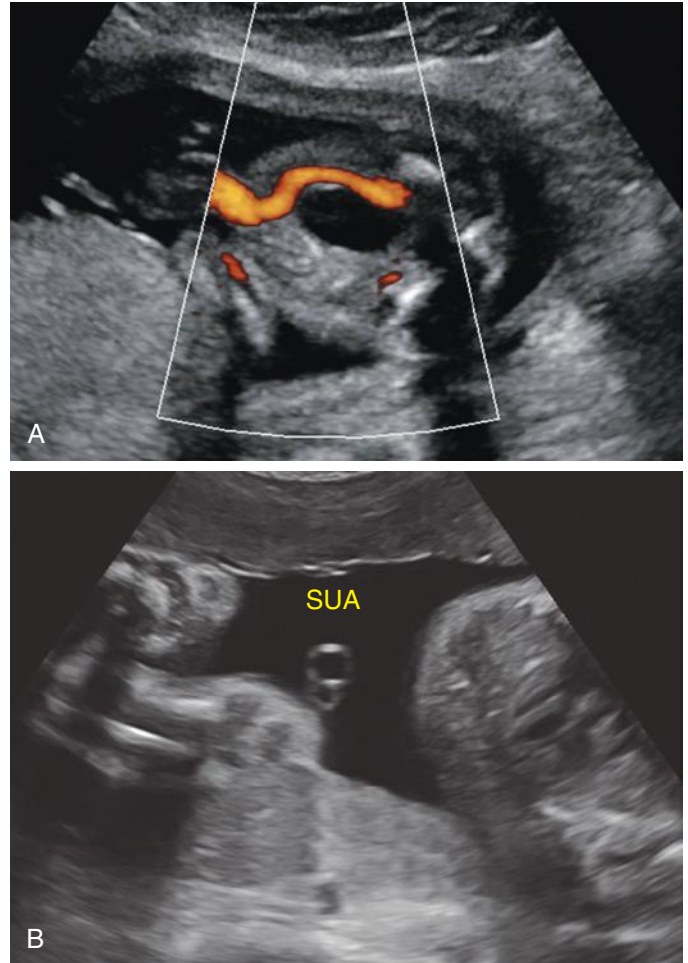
A, Transverse power Doppler ultrasound image of the fetal pelvis demonstrating the presence of a single umbilical artery coursing adjacent to the bladder. B, Cross section of a free loop of umbilical cord showing the larger umbilical vein and the adjacent small single umbilical artery (SUA).
